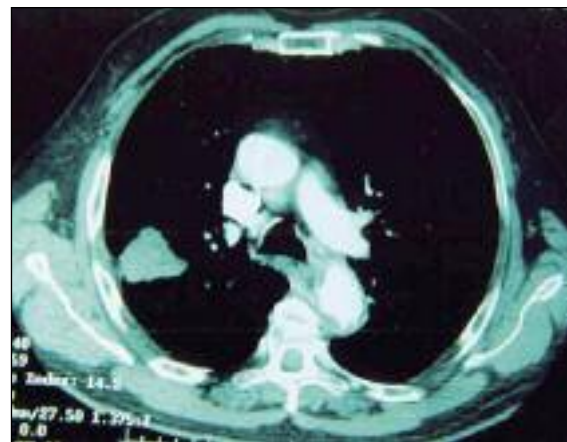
CT scan of chest.
